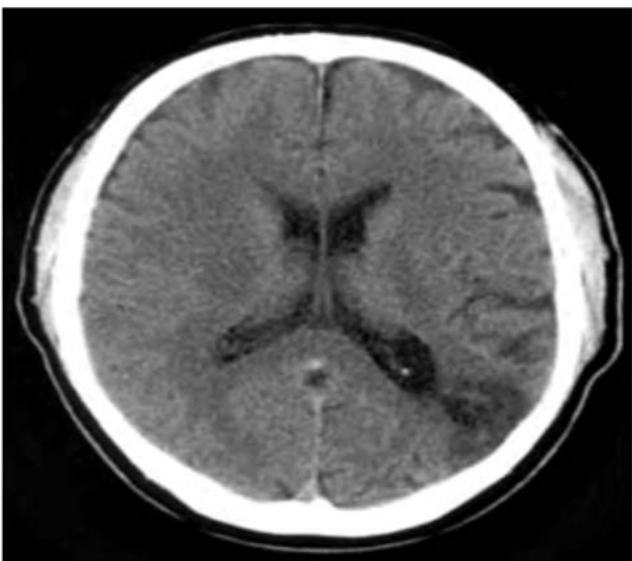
CT- scan of brain (Acute Ischemic Stroke) Pt's name: Mr. Makbul Age: 59.
